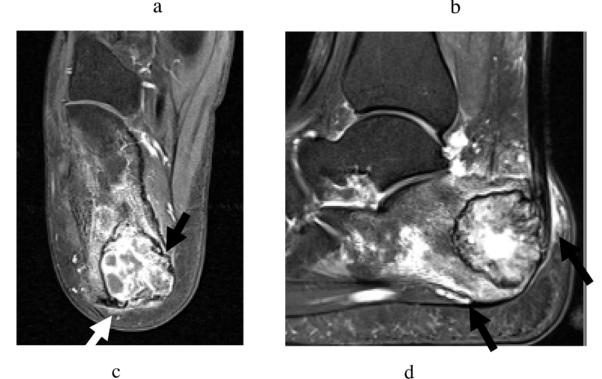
Chondroblastoma. Lateral view of the ankle (a) shows a lytic, well-defined lesion in the calcaneus with internal chondroid matrix (arrow). T2W Dixon MR imaging with in-phase (b) and water (c) maps show extensive marrow edema and some periosteal edema (white arrows) around a well-defined lesion (black arrow). Sagital post-gadolinium fat-suppressed T1W imaging (d) shows heterogeneous enhancement and periosteal enhancement (arrows).
